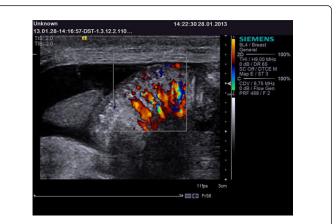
Echogram of the intestinal loop in a neonate with gastroschisis, day 2 postop. (B-mode, color Doppler mapping). Longitudinal linear B-mode scanning evaluates the peristalsis, diameter and intestinal wall thickness. Doppler imaging evaluates the blood flow patterns in the intestinal wall.
